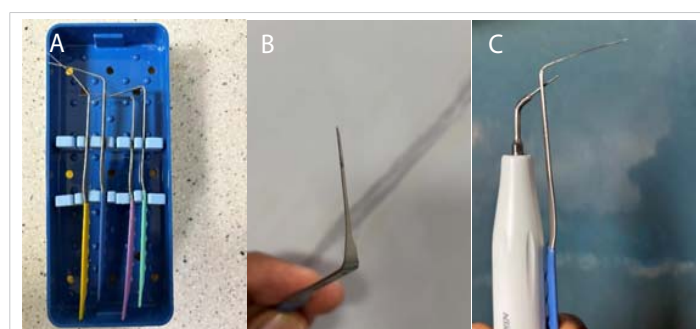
Sonic Steel diamond-coated probes, Laschal FXP System. Laschal Surgical Inc (A) Kit with various angulations. (B) Diamond-coated tip. (C) An ultrasonic tip is inserted into the probe to transmit indirect ultrasonic energy.
